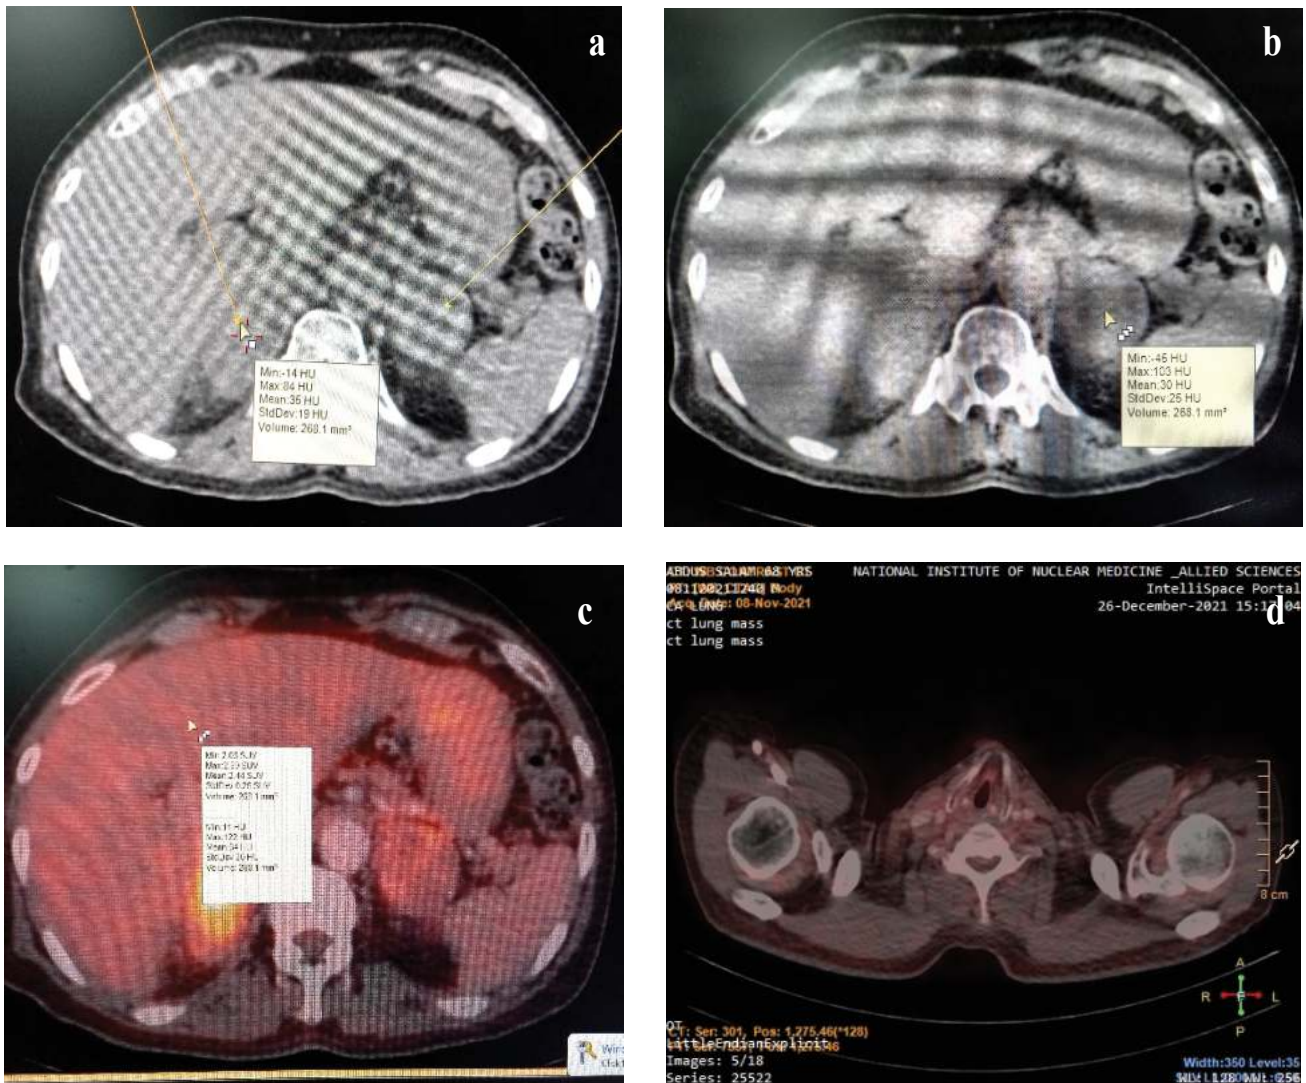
From left to right- upper row demonstrates non enhanced CT images of upper abdomen showing enlarged both adrenal glands (arrows) with HU mean of a) right gland 35 and b) left gland 30; Lower row demonstrates c) transaxial fused ¹⁸F-FDG PET-CT image of liver showing SUVmax 2.9 and d) laryngeal area showing no mass lesion
